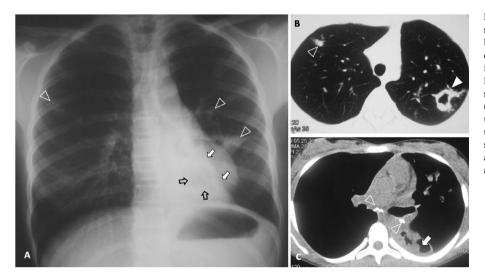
Chest imaging of patient 1 A: Chest x-ray showing large cavities at the left lower lobe (open black arrows) adjacent to a retrocardiac collapse-consolidation (white arrows) and oval and nodular infiltrates at the mid-lung fields (open arrowheads). B: HRCT transverse section through the upper lobes showing a nodular lesion at the right upper lobe (open arrowhead) and a cavitary lesion at the left upper lobe (arrowhead). C: HRCT transverse section through the lung bases demonstrating calcified small subcarinal and left hilar nodes (open arrowheads) and a cavity (arrow) inside the collapse-consolidation at the left lower lobe.
